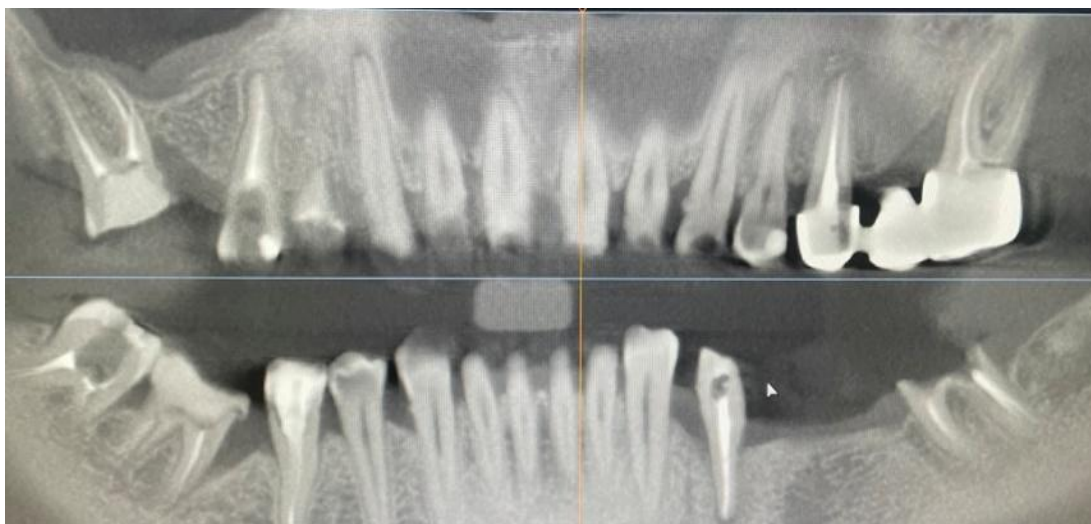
Cone-beam computed tomography
